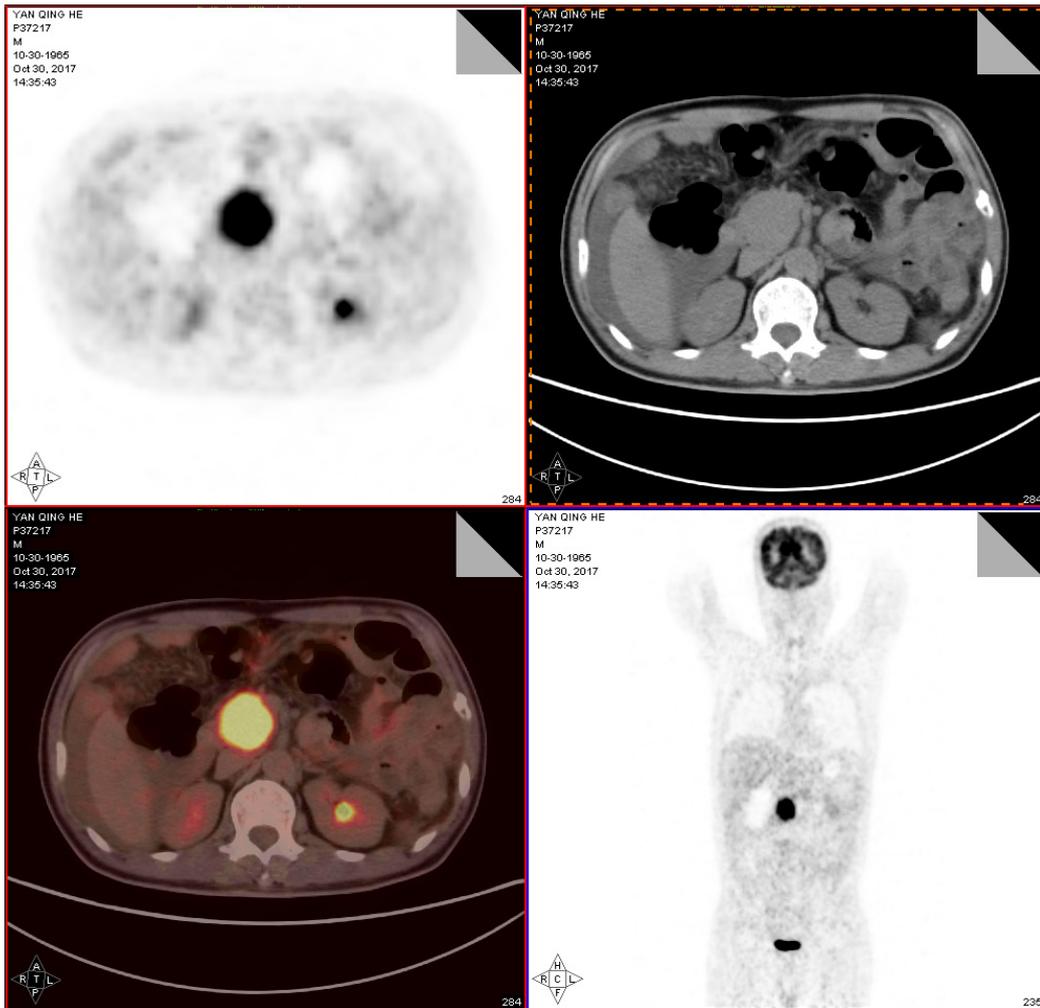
For further evaluation, F – 18 FDG PET/CT was done, Scintigraphy revealed a hypermetabolic lesion (arrow), which had intense FDG uptake, SUV max = 22.8. corresponding to the lesion on abdominal CT
